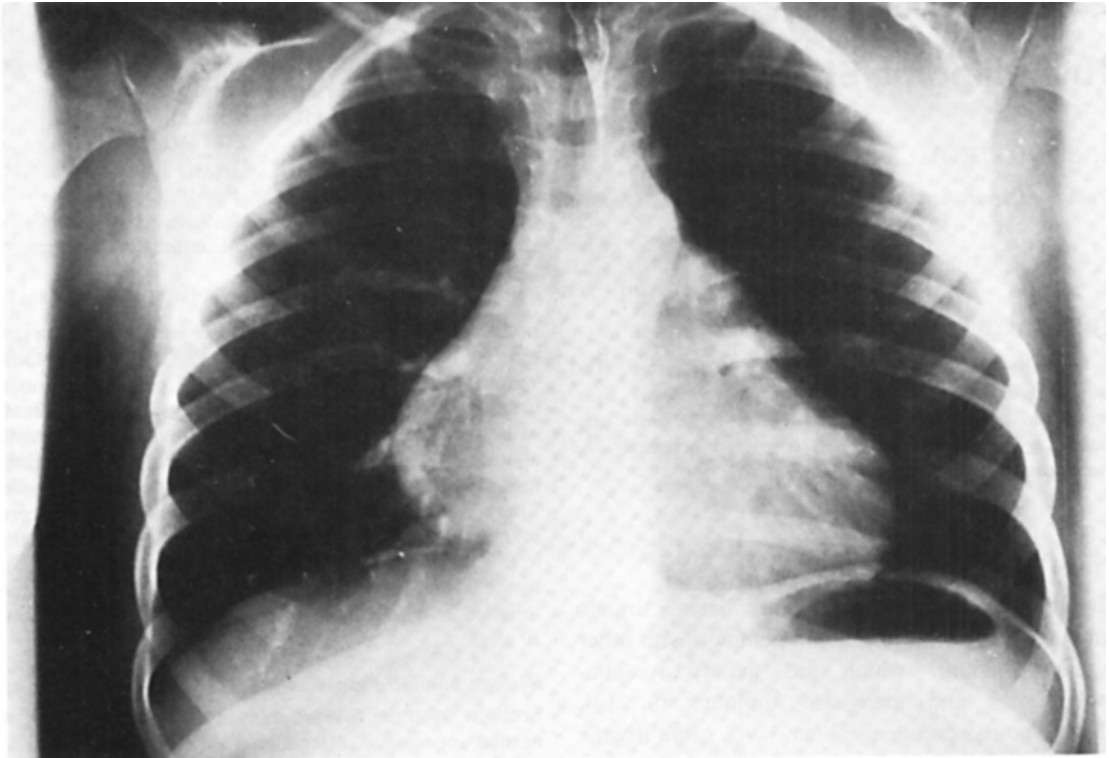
Chest X-ray showing mediastinal mass giving rise to a peculiar right cardiac contour.
